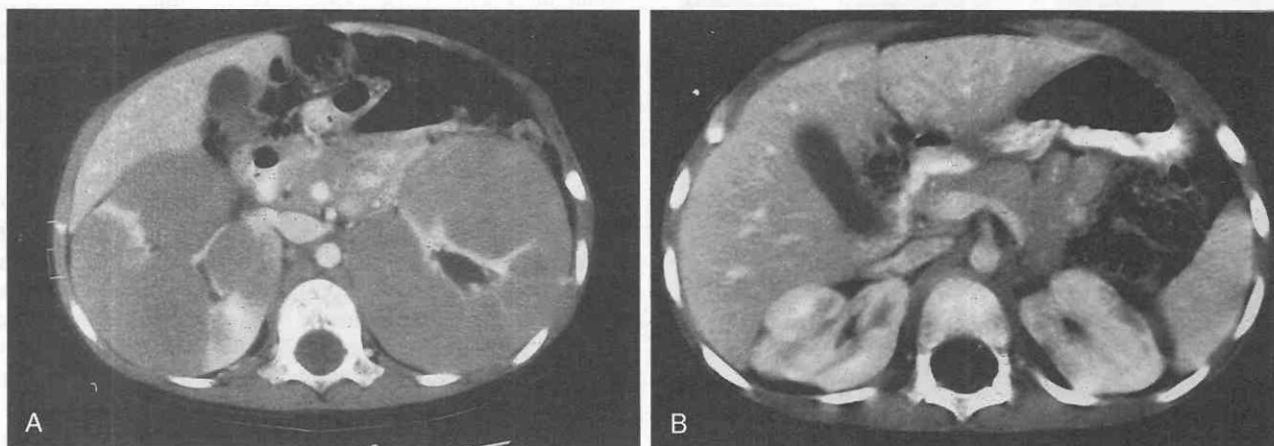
Burkitt's lymphoma with renal involvement in a 3-year-old boy. *A*, Contrast-enhanced CT axial image through the kidneys. Both kidneys are massively enlarged and almost completely replaced by multiple, low-attenuation, nonenhancing solid masses. *B*, Contrast-enhanced CT axial image through the kidneys 8 months later. The renal masses are no longer present and the kidneys are now normal in size. However, the renal margins are now irregular and somewhat lobular.
